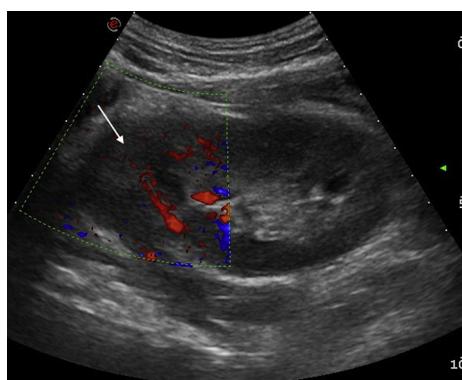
One month after the trauma, color Doppler ultrasonography showed the reappearance of a vascular signal in the upper pole of the left kidney (arrow).
